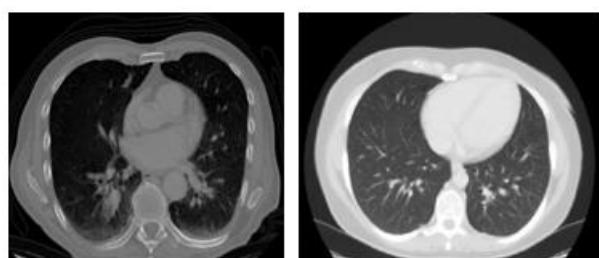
3. The above images represent Large cell carcinoma of the lungs on the left and a Normal CT Scan on the right.
